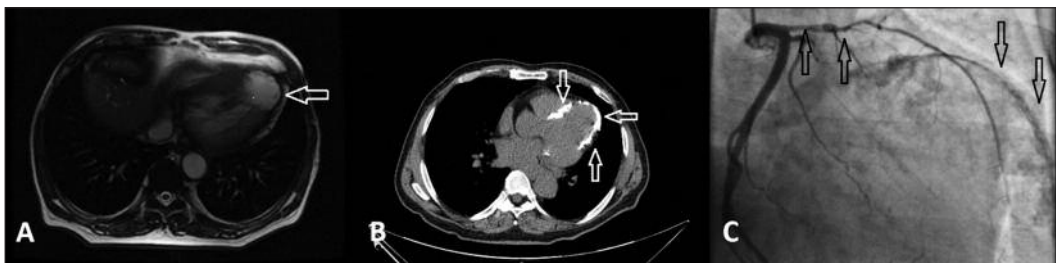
A) MRI image (aneurysmal sac), B) CT image, C) Coronary angiogram (LAD proximal lesion and calcification line).
